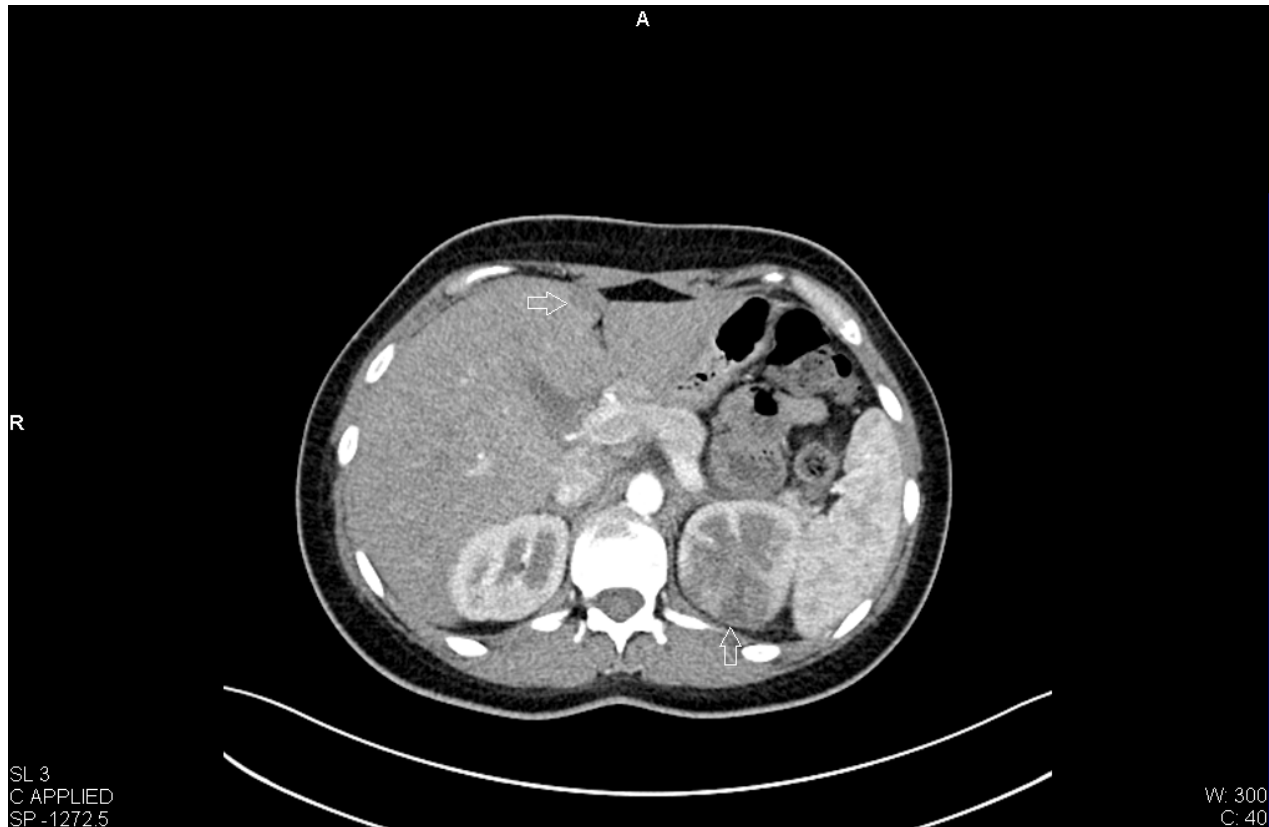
CT of the left kidney showing multiple hypochoic areas of up to 2 cm in diameter.
